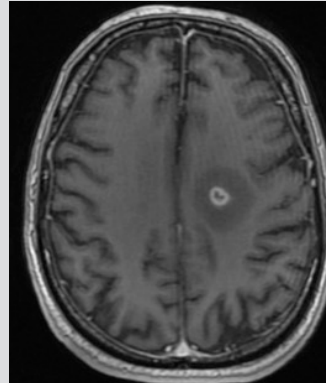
T1 weighted MRI of the brain showing nocardial abscess
